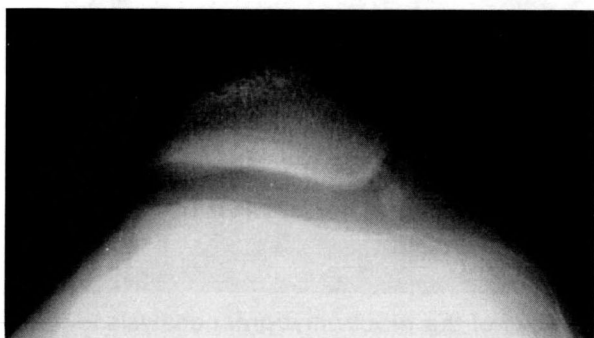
A preoperative roentgenogram of the knee in case 2. : The tilting angle was 26° and the lateral shift ratio was 38%.
